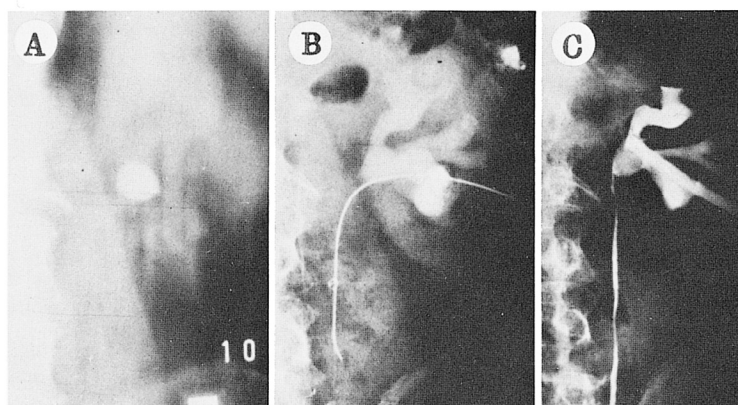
Case 5. A, plain film shows calculus in renal pelvis. B, J-guide wire passes stone after percutaneous puncture. C, anterograde pyelography shows already partially collapsed collecting system with 26F nephrostomy in place after dilation.
